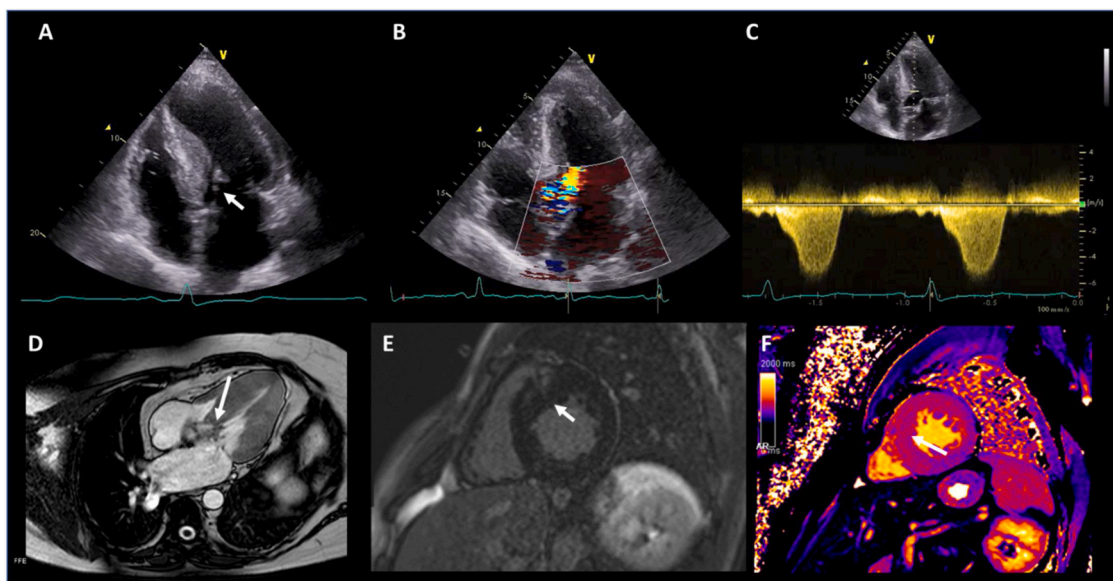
42 years old male patient with oHCM and typical imaging findings. Transthoracic echocardiogram: (A,B) asymmetric septal wall hypertrophy with turbulence in the left ventricular outflow tract and mitral leaflet elongation (arrow); (C) characteristic continuous-wave Doppler signal with a late-peaking dagger-shaped appearance. Cardiac Magnetic Resonance: (D) typical artifact due to turbulence jet across the LVOT (arrow); (E) LGE in the hypertrophied anterior septal myocardium; (F) patchy areas of prolonged T1 values in the anterosseptal segment in short-axis T1 mapping. oHCM: obstructive hypertrophic cardiomyopathy; LVOT: left ventricular outflow tract; LGE: late gadolinium enhancement.
